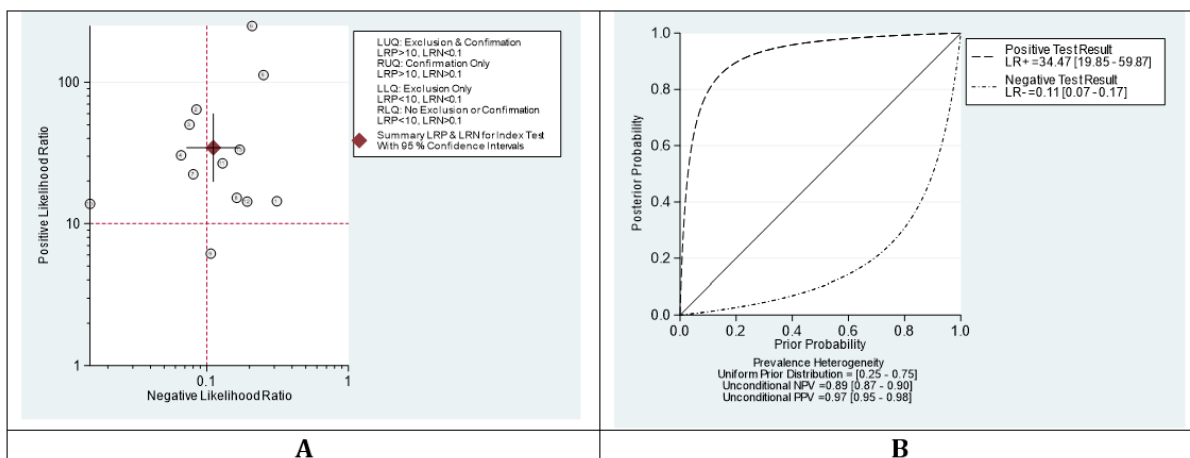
A: The likelihood ratio (LR) scattergram of ultrasonography for diagnosis of skull fractures; B: Probability modifying plot of ultrasonography. NPV: negative predictive value; PPV: positive predictive value; LUQ: left upper quadrant; RUQ: right upper quadrant; LLQ: left lower quadrant; RLQ: right lower quadrant; LRP: positive likelihood ratio; LRN: negative likelihood ratio.
